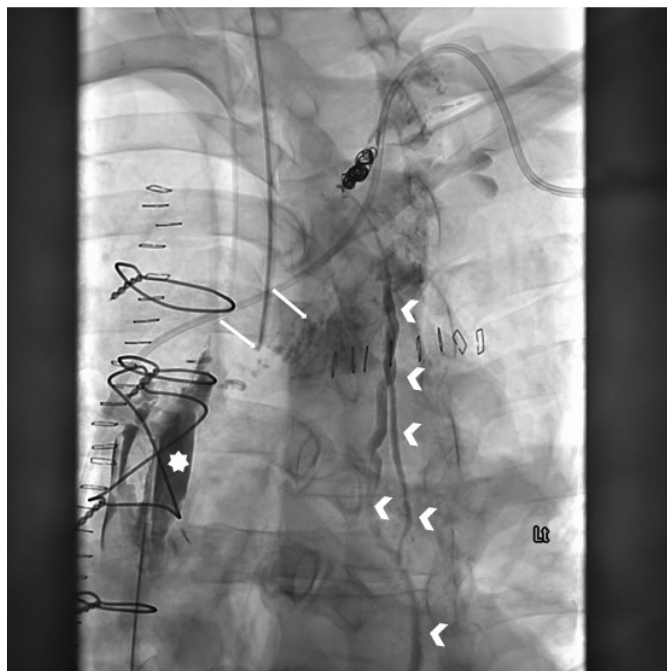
Single anterior-posterior X-ray image from lymphangiogram. Evidence of lymphatic leakage in the anterior mediastinum (*) near the sternotomy from a branch (arrow) of the thoracic duct (arrowhead).
